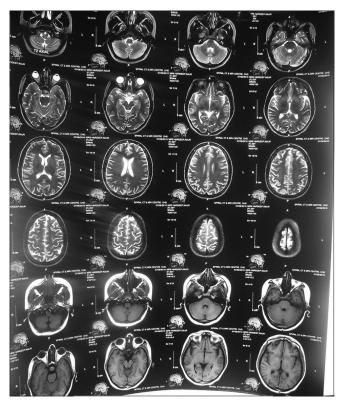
MRI image of the brain showing pituitary macroadenoma
